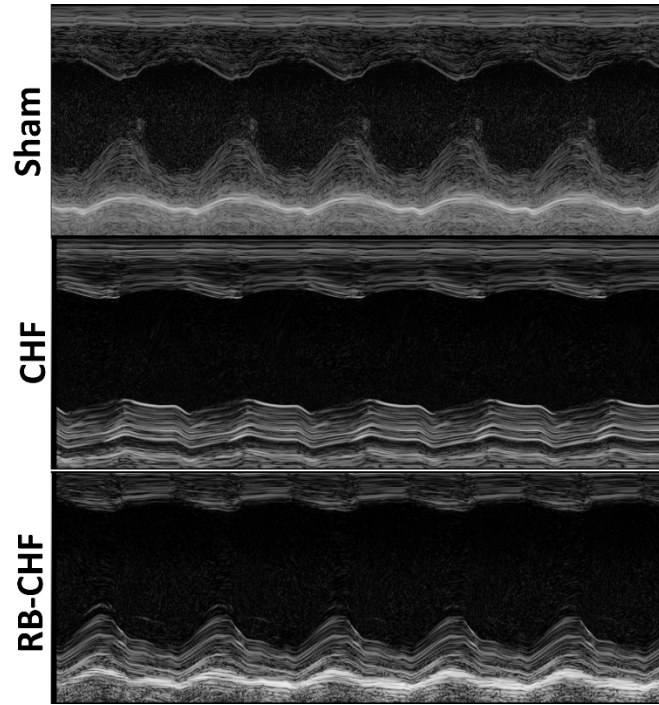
Qualitative assessment of echocardiogram images in M-mode. Visualized are the posterior and anterior walls of the cardiac left ventricle during systole and diastole as indicated by the observed peaks and troughs, respectively.
